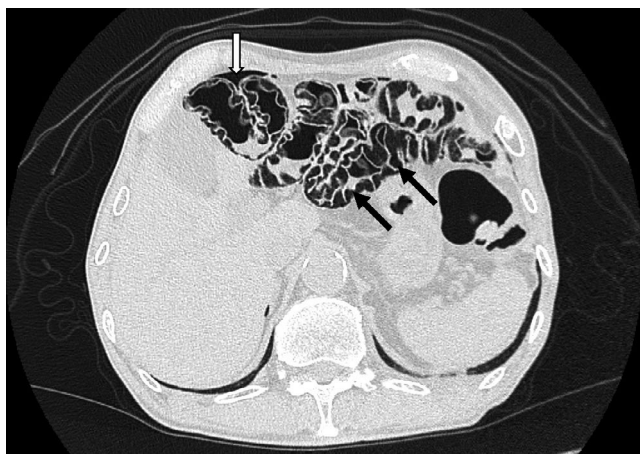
Abdominal CT without contrast on admission shows extensive intramural gas in the small intestine (black arrows) and a small amount of free air (white arrow)
